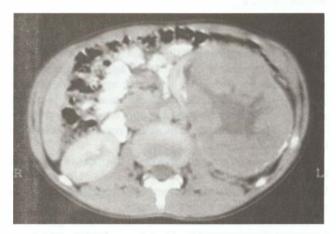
Abdominal CT in 6-yr-old boy with hematuria and abdominal mass suggests Wilms tumor
